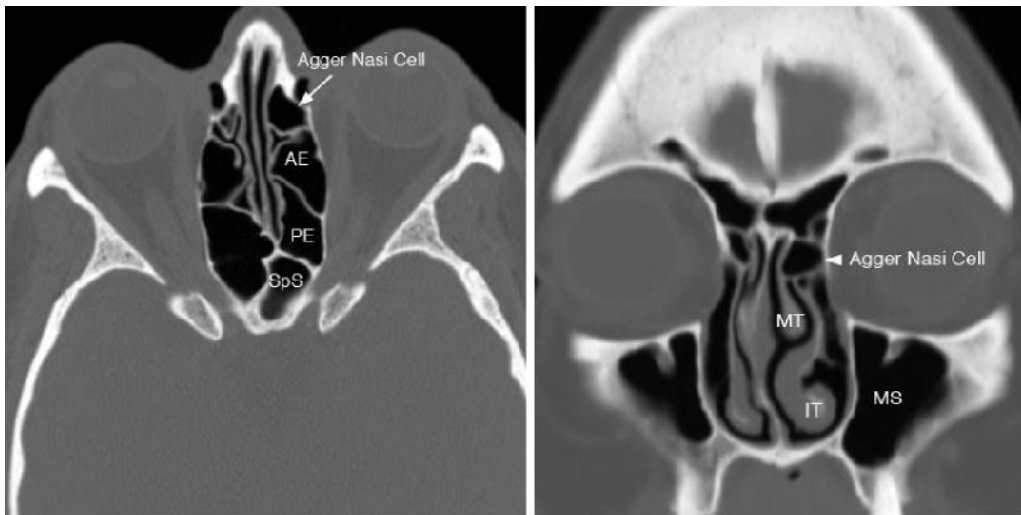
Axial and Coronal CT images showing Agger Nasi Cell [AE-Anterior ethmoid, PE-Posterior ethmoid, SpS-Sphenoid sinus, MT-Middle turbinate, IT-Inferior turbinate, MS-Maxillary sinus,]
